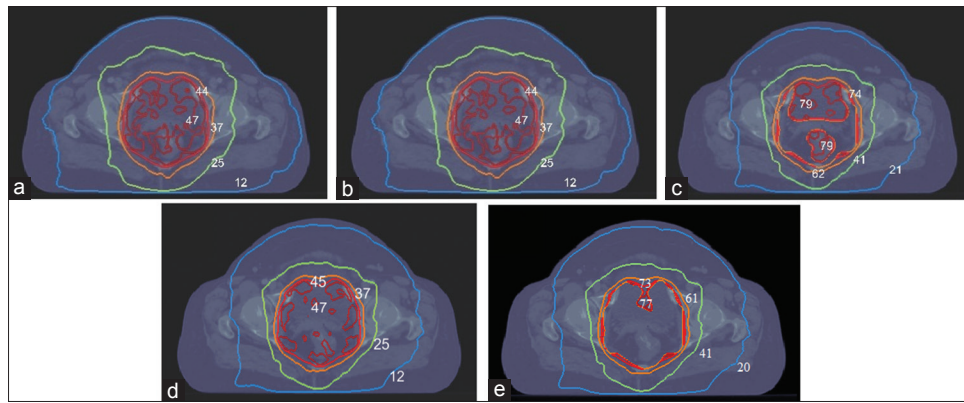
Absolute physical isodose (a), iso-EQD₂ (b) and iso-BED (c) curves display with special priority given to OARs radiobiology and iso-EQD₂ (d) and iso-BED (e) displays with special priority given to PTV radiobiology over the same axial slice of the CT-Cube
